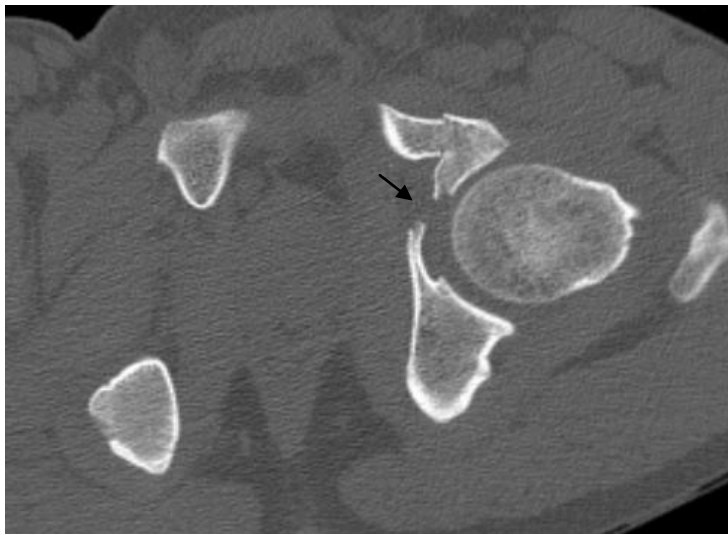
Right transverse acetabular fracture. Axial (A and C),and 3-D CT reconstruction(B) Pelvic computed tomography (CT) scan of a 28 years old male patient Computed tomography (CT) scan shows the vertically oriented transverse fracture (arrows) of the left acetabulum is well depicted on CT scans. Posterior right hip dislocation and intra-articular bony fragments (C) also noted.
